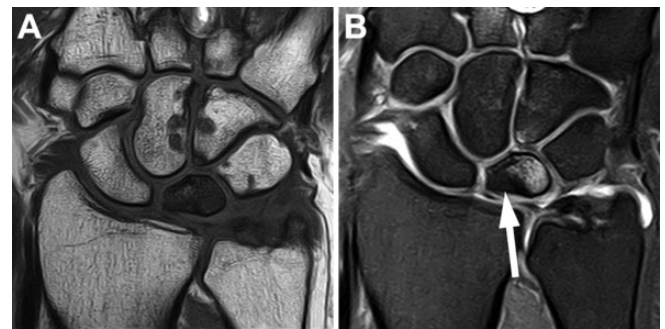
A 34-year-old patient diagnosed with stage 2 Kienböck disease. (A) A coronal T1-weighted magnetic resonance imaging (MRI) scan shows uniform, low signal intensity within the lunate. (B) A coronal fat-suppressed T2-weighted MRI scan shows low signal intensity over the radial aspect of the lunate, indicating partial necrosis (arrow). (Reproduced with permission from Llopis E, Restrepo R, Kassarian A, Cerezal L. Overuse injuries of the wrist. *Radiol Clin North Am*. 2019;57[5]:957-976.)
